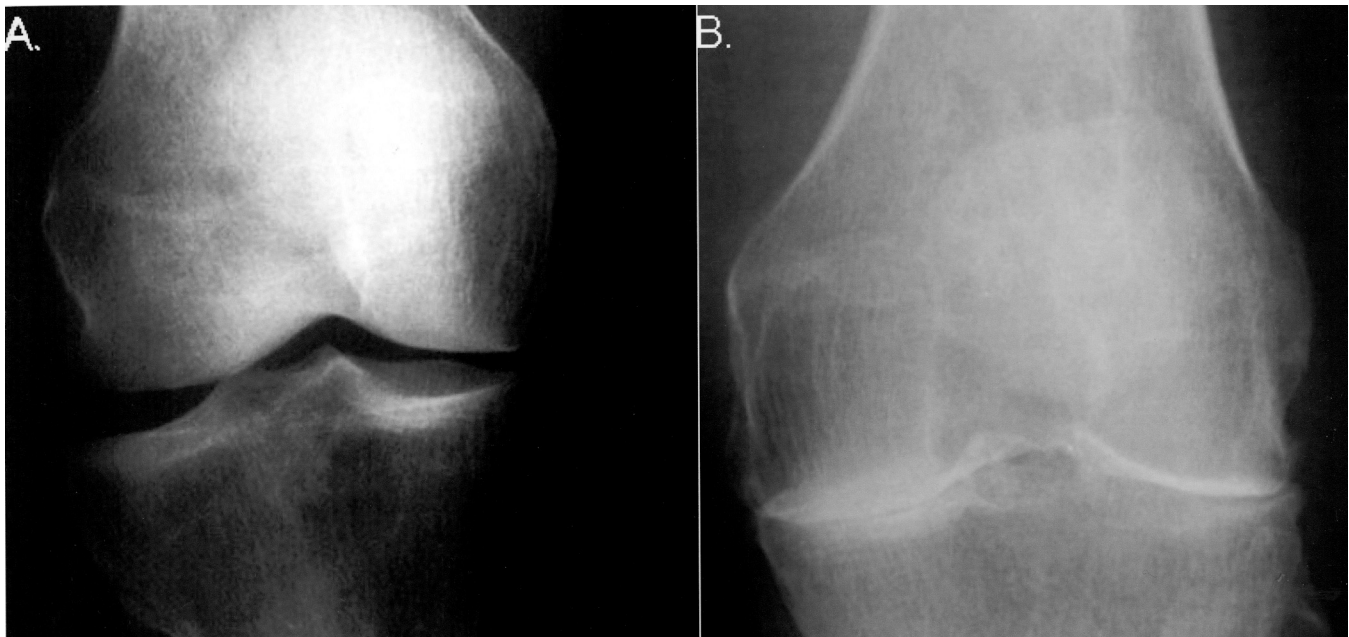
Bilateral knee radiographs (anterior view) showing complete joint destruction in the left knee compared to the right knee, 2 weeks following the onset of septic staphylococcal arthritis.
